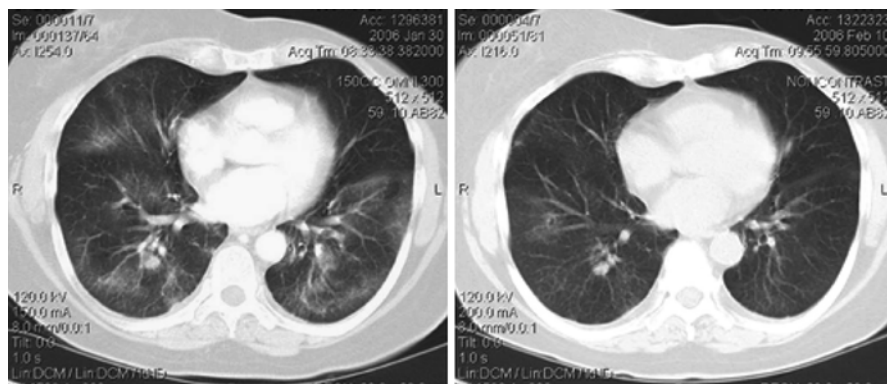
Ridaforolimus-induced pneumonitis (*left*) with radiographic resolution (*right*) 10 days after treatment withheld [7]
